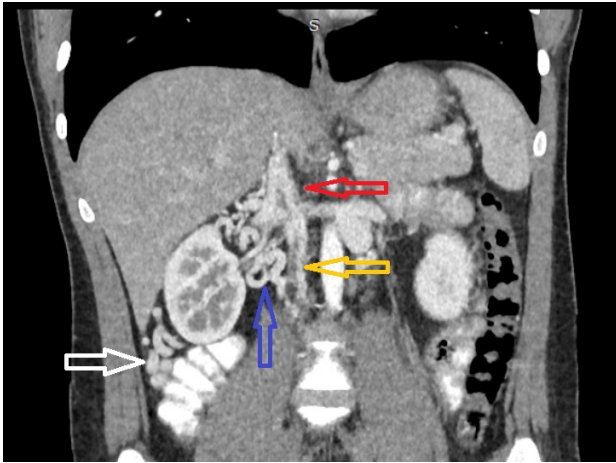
Coronal view of CT scan of IVCA showing incomplete IVC from suprarenal (red arrow), multiple tortuous collateral draining the right kidney (blue arrow), tortuous lumbar veins (yellow arrow) and multiple tortuous retroperitoneal veins (white arrow)
